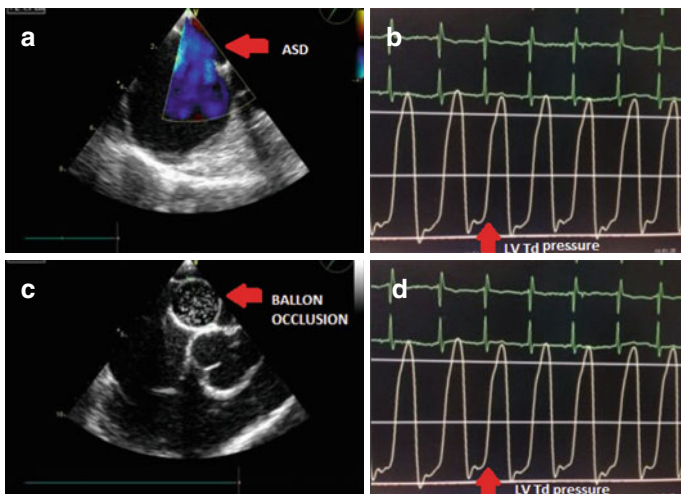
Percutaneous closure of large ASD in adult. (a) Large ASD with significant left-to-right shunt at color Doppler analysis. (b) LV end-diastolic pressure before ASD temporary occlusion. (c) Dynamic ASD balloon occlusion test performed from the right atrium. (d) No change in LV end-diastolic pressure during balloon inflation is recorded
